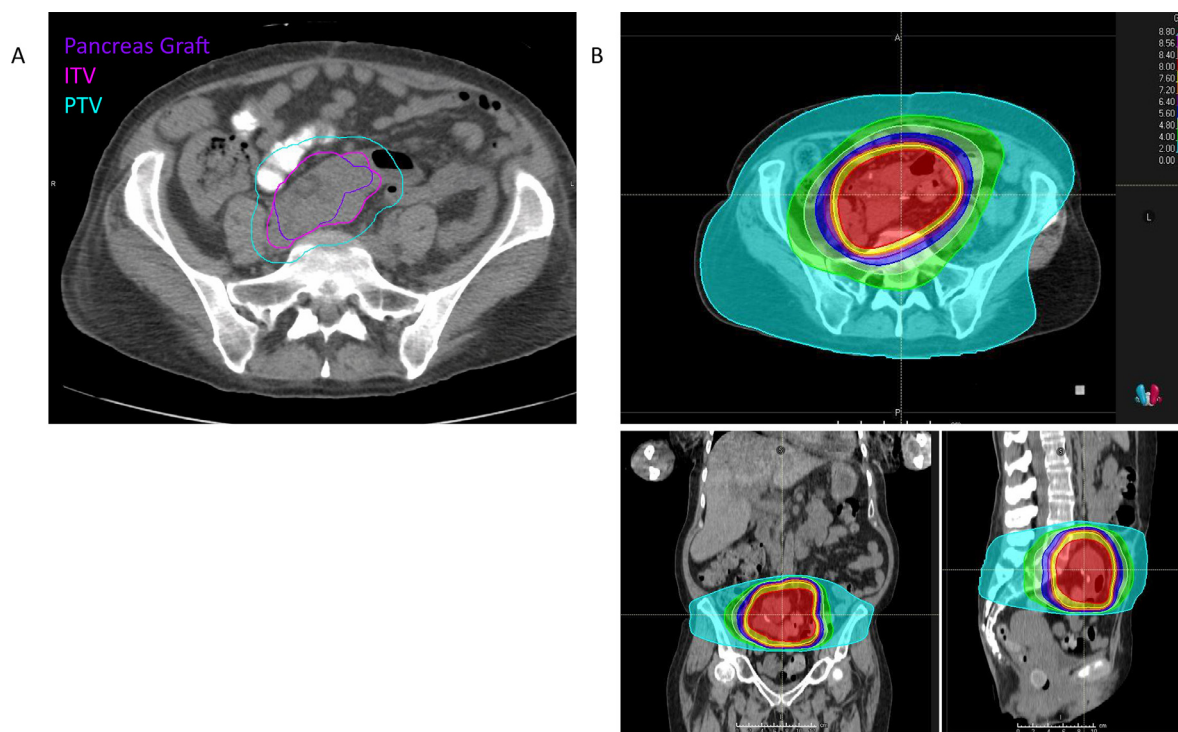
Representative computed tomography images of A, local graft radiation treatment volumes and B, total treatment isodose lines. A, Contours represent pancreas graft on planning image set (purple), internal target volume (ITV) accounting for motion seen on corresponding diagnostic imaging (pink), and planning target volume (PTV, aqua), representing a 1-cm expansion from ITV. B, Isodose color wash representing total dose coverage, with red representing 8 Gy and blue representing 2 Gy.
